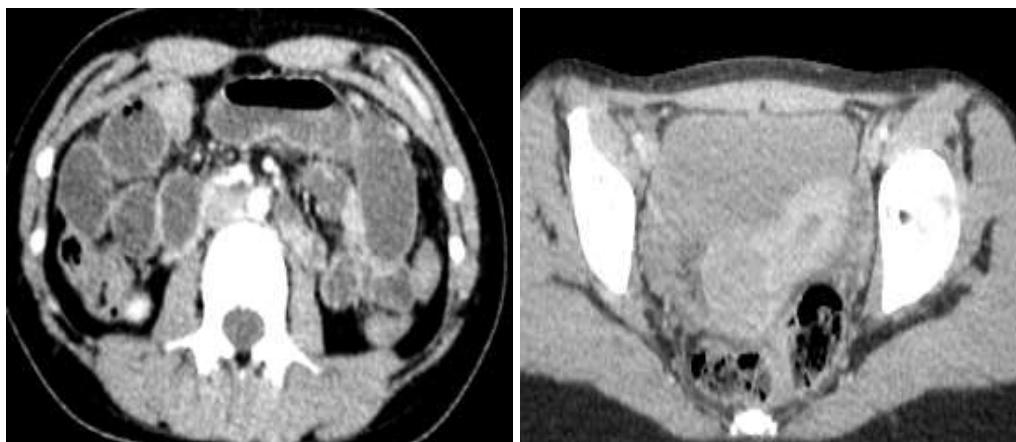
Abdominal-pelvic CT image showing hydroaeric distension of the ileal ansae upstream of irregular thickening of the ileo-caecal junction
